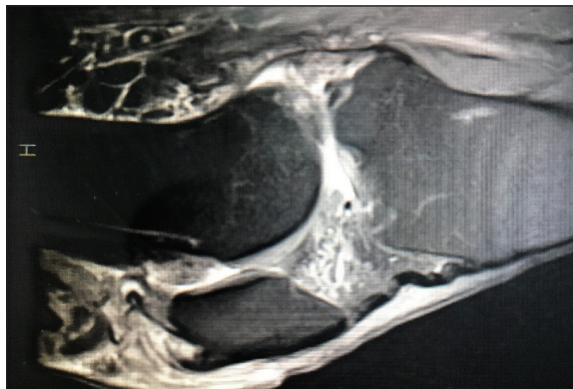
MRI demonstrated rupture of quadriceps tendon with large effusion.
